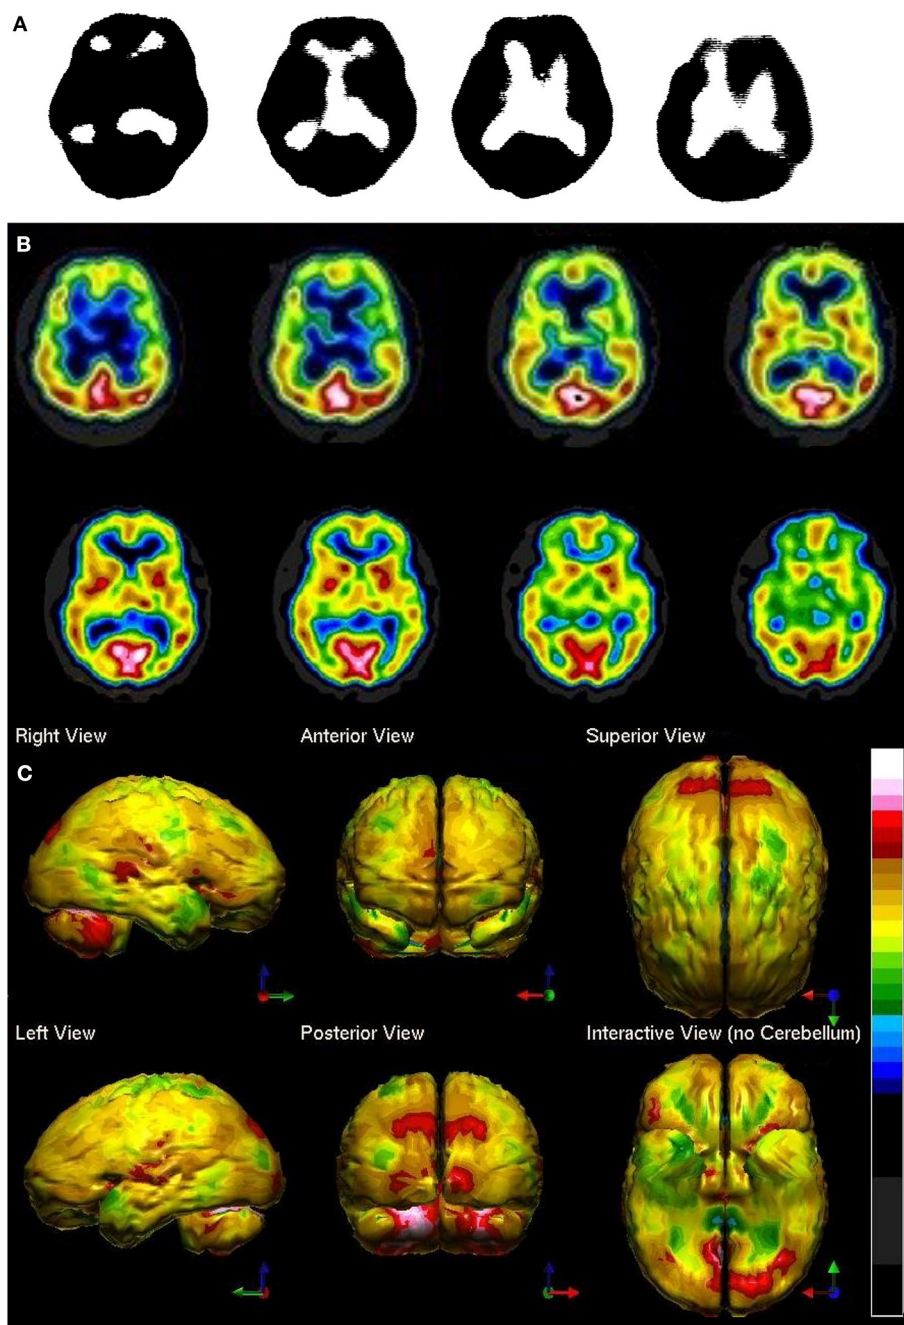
Perfusion SPECT scan of normal control. (A) Four horizontal tomograms from a ^{99m}Tc -ECD perfusion SPECT scan performed on a single-headed gamma camera in 1989 [The figure was originally published in JNM. © SNMMI (25)]. (B) Eight horizontal tomograms from a modern ^{99m}Tc -HMPAO perfusion SPECT scan obtained from a dual-headed gamma camera. The color scale is scaled relative to the patient's mean cerebral perfusion. Mean blood flow (72%) is in yellow. Color shifts occur at approximately every 0.5 SD (3%) relative to the patient's mean. Details of the brain can be appreciated, including the thalamus, head of the caudate nuclei, lentiform nuclei, anterior cingulate gyri, and distinct cortical regions. (C) The modern SPECT scan displayed in 3-dimensional reconstruction. Increased perfusion in the visual cortex and the slightly lower average perfusion level in the temporal lobes bilaterally can be appreciated. The color scale is the same as (B).
